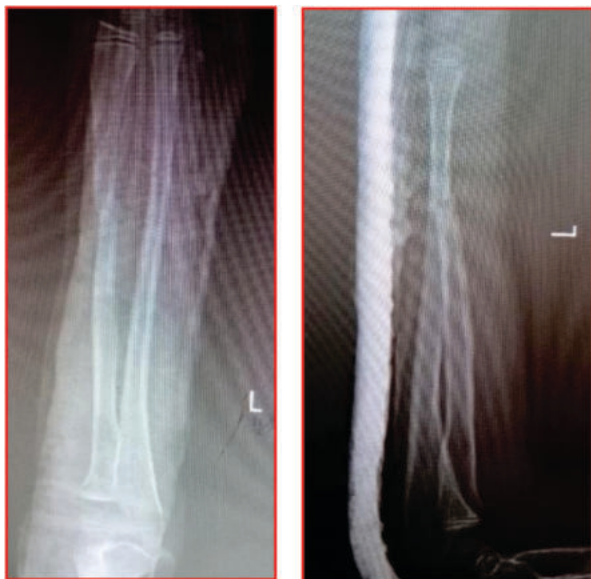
Pre-operative X-rays
